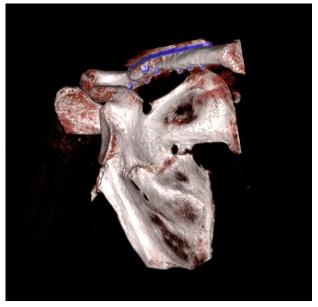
Three-dimensional computed tomographic scan of the right shoulder after arthroscopy. Note that the protruding lateral border of the right scapula has been resected.
